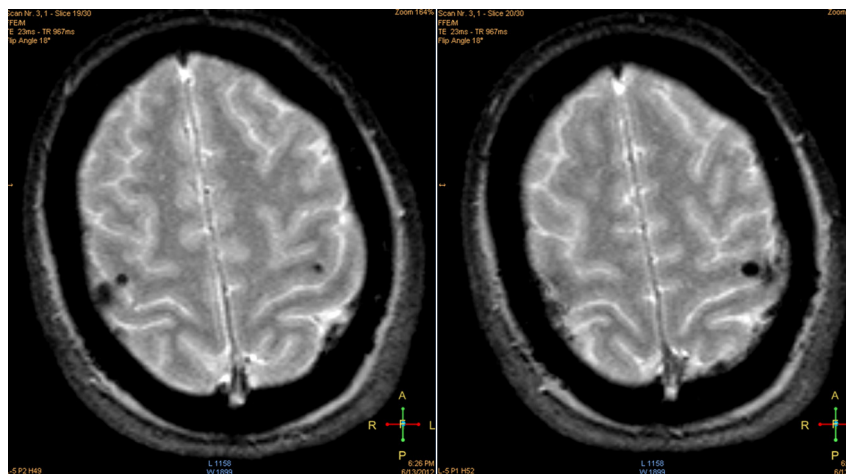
T1-weighted magnetic resonance images in axial view obtained 24 h after stem cell transplantation. Signal void is observed in the frontal motor stripes where stem cells were transplanted.
